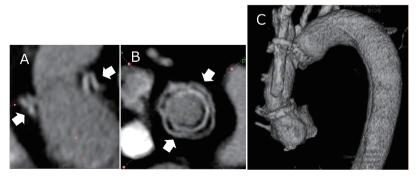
Computed tomography findings after the first surgery
